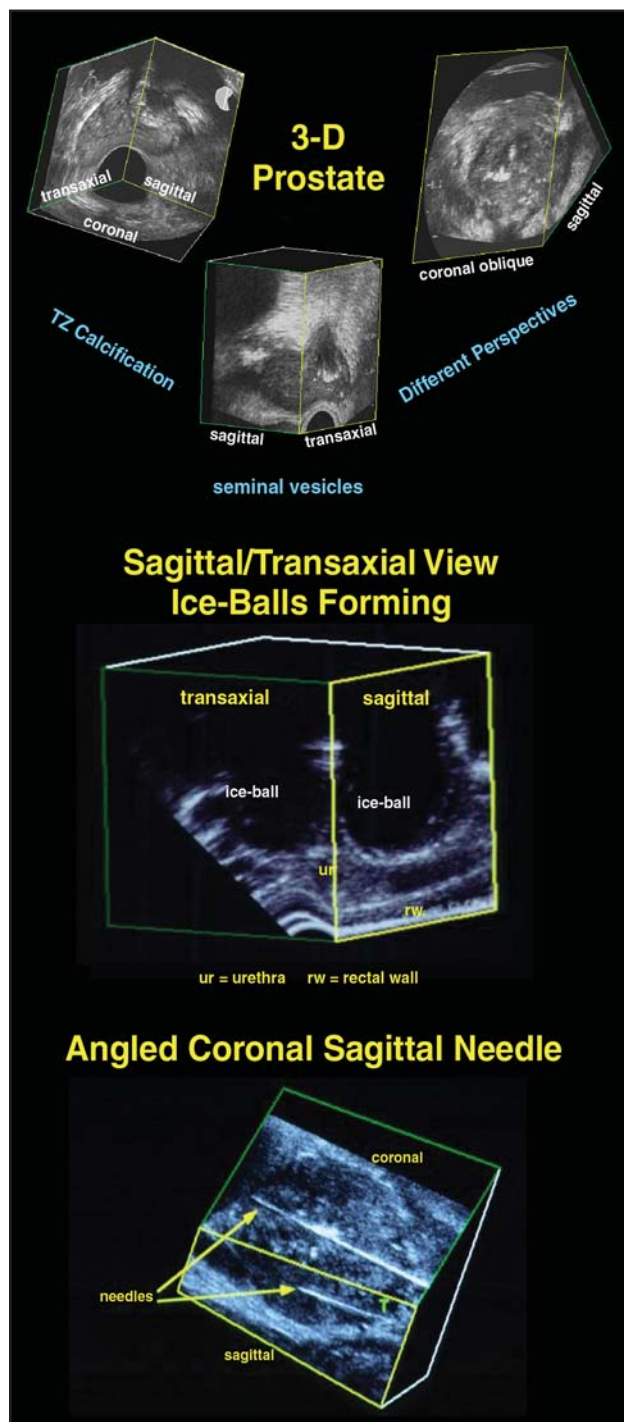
Visualization of 3-D ultrasound, needle placement guidance, and monitoring of ice-ball formation during cryoablation.
